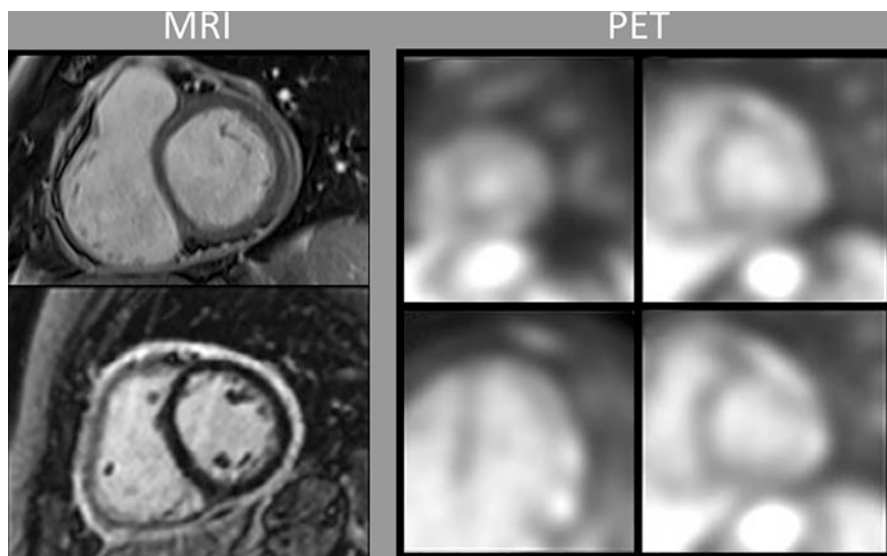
Patient with pericarditis. Left: MRI short-axis views showing significantly increased pericardial thickness (top) with circumferential late gadolinium enhancement (bottom). Right: FDG-PET of the same patient showing intense pericardial FDG uptake. PET views clockwise from top left: apical short axis, mid-short axis, basal short axis, horizontal long axis
